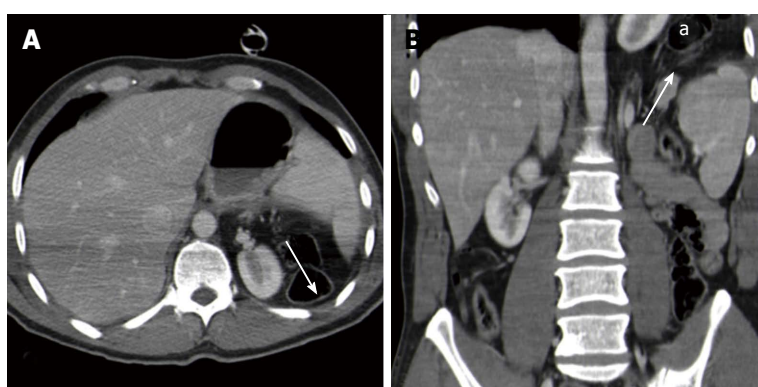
Computed tomography findings in blunt diaphragmatic lesions - diaphragm non-visualization. These 3 mm thick axial (A) and coronal (B) multiplanar reconstructions show a lack of diaphragm visualization, without the clear demonstration of a tear (arrows), associated with intra-thoracic viscera herniation (a).
